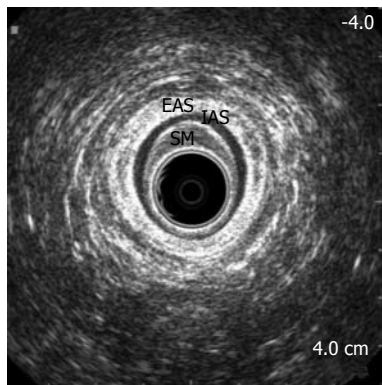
Endosonographic image showing thickening of the submucosa. IAS: Internal anal sphincter; EAS: External anal sphincter; SM: Submucosa (hypoechoic area is hemorrhoidal).
